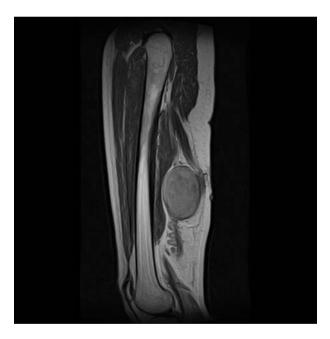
Magnetic resonance image of the left thigh shows well-defined expansive mass associated with the sciatic nerve in the posterior compartment
